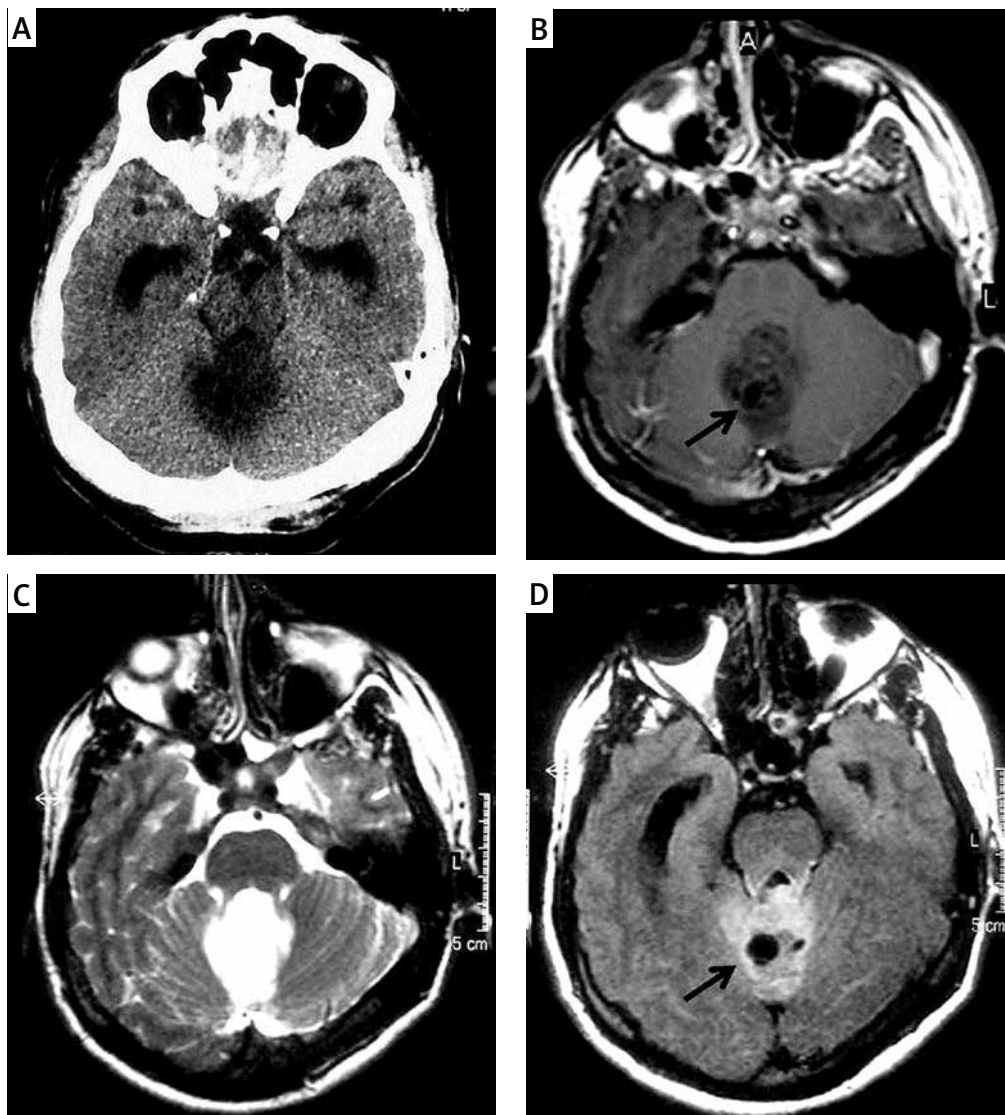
A) Non-contrast computed tomography scan shows a hypodense lesion at vermis. B) On T1 weighted magnetic resonance scans this lesion shows heterogeneous contrast enhancement and a cystic component also is found (arrow) in the lesion. C) The lesion seems hyperintense on T2 weighted magnetic resonance imaging (MRI). D) On flair weighted MRI images the lesion seems hyperintense but the cystic component is hypointense (arrow).
